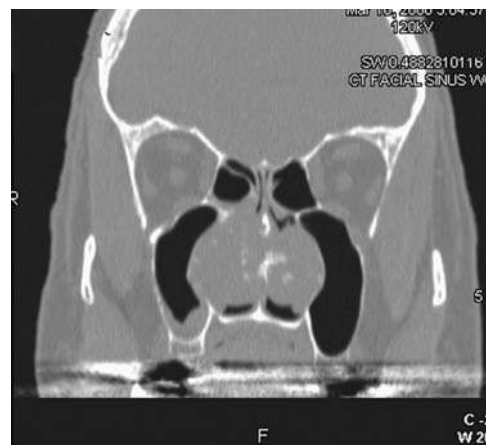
CT scan of a nasal cavity chondrosarcoma. Note the calcifications seen within the tumor.
